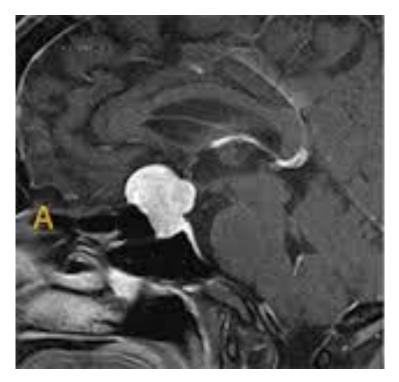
MRI – BEFORE SURGERY
